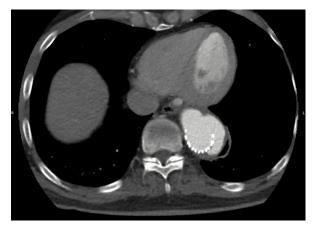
Computed tomography angiogram shows the type lb endoleak with resultant aneurysmal dilation from false lumen pressurization.
